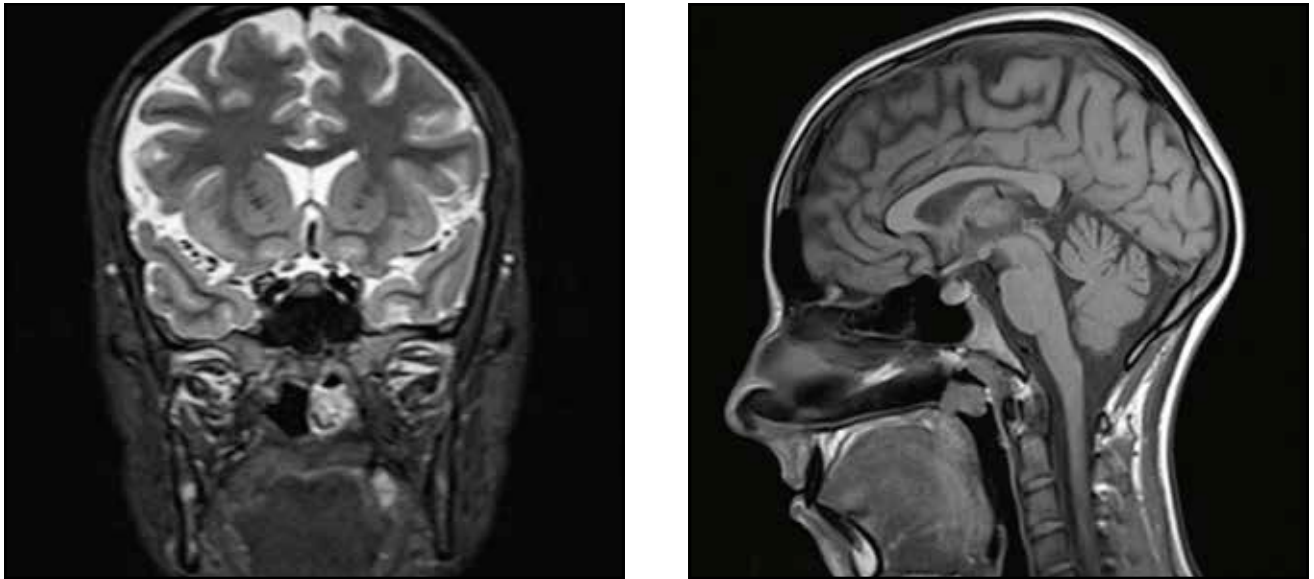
Head and neck angio-MRI (sagittal and coronal slices): space-replacing process, vegetative, anterior to the tubal torus of the left side, with obstruction of the tubal pore; axial dimension of 18/20mm and 17 mm craniocaudally; irregular contour; heterogeneous structure.
